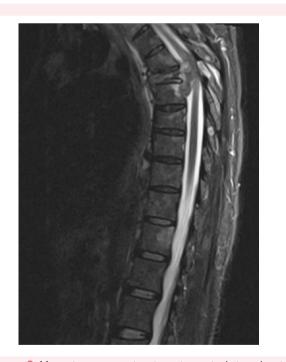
Magnetic resonance imaging spine sagittal view showing D5/D6 fracture with cord compression.
